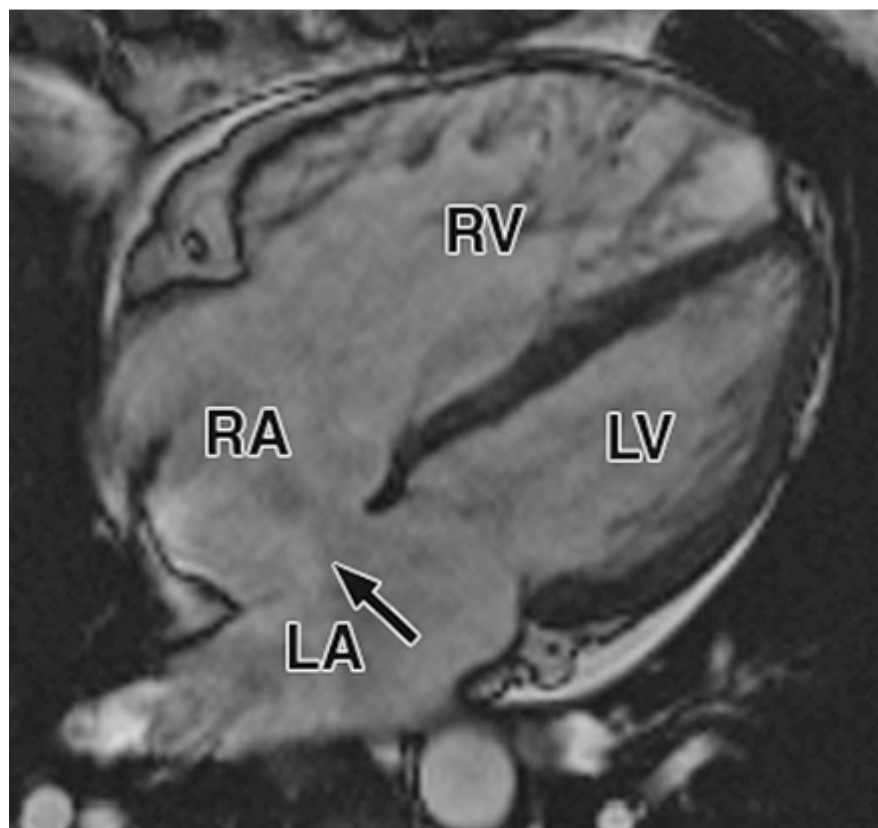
large atrial septal defect in MRI
